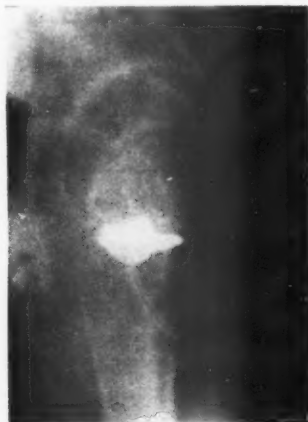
Radiograph with the patient erect demonstrating that heavy material will readily drain in this posture.
